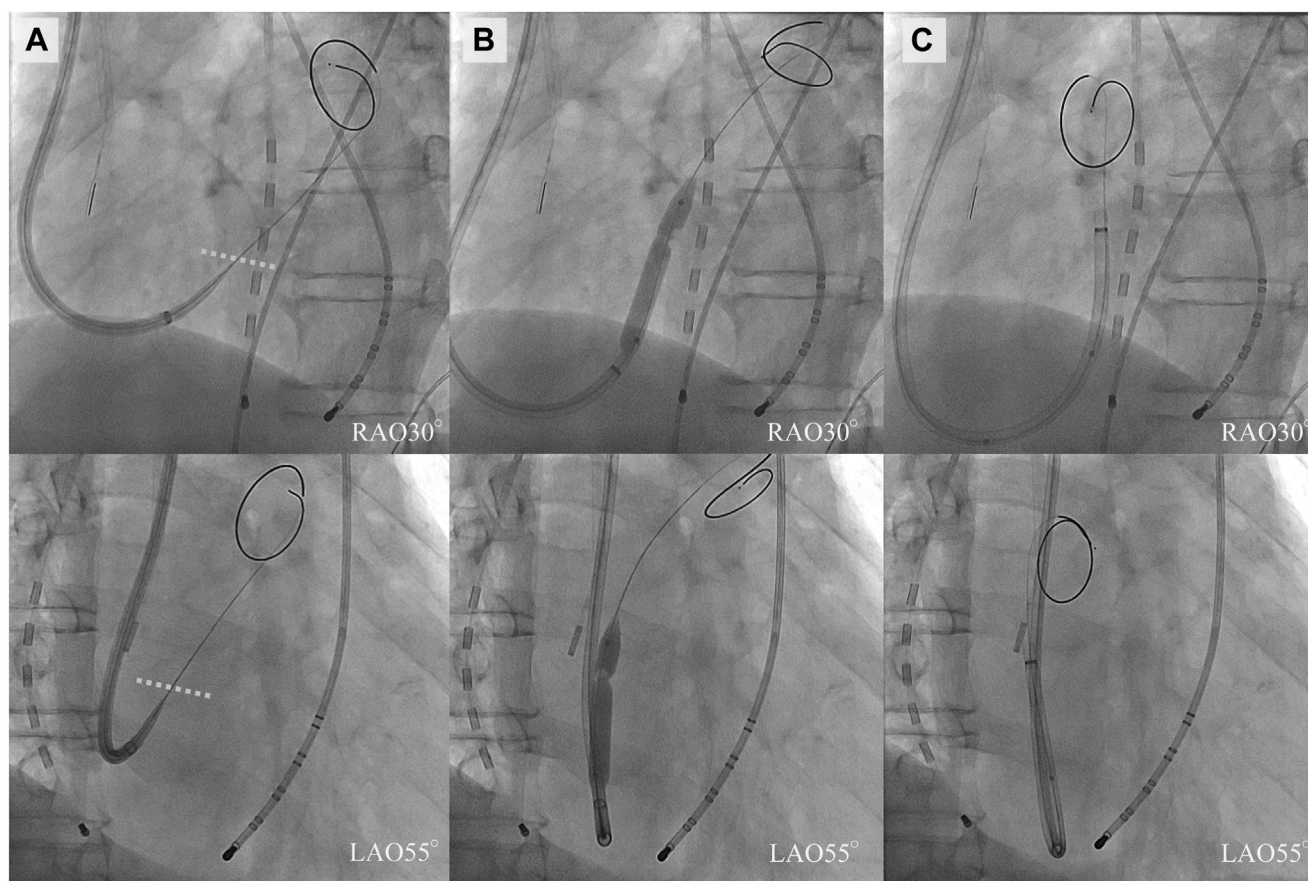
Fluoroscopic images of the transseptal puncture (TSP) procedure from the right subclavian vein. The top panels show the right anterior oblique 30° (RAO30°) view, and the bottom panels show the left anterior oblique 55° (LAO55°) view. TSP was performed with intracardiac echocardiography imaging to confirm atrial septal tenting. A: Images of the SupraCross wire (Baylis Medical, Montreal, Canada) crossing the atrial septum and into the left superior pulmonary vein. The dashed line indicates the atrial septal plane where the SureFlex sheath (Baylis Medical) faced difficulty passing. B: Atrial balloon septoplasty (ABS) using a Mustang balloon (Boston Scientific, Marlborough, MA). C: Images of the successful insertion of the SureFlex sheath into the left atrium after ABS, demonstrating a successful TSP.
